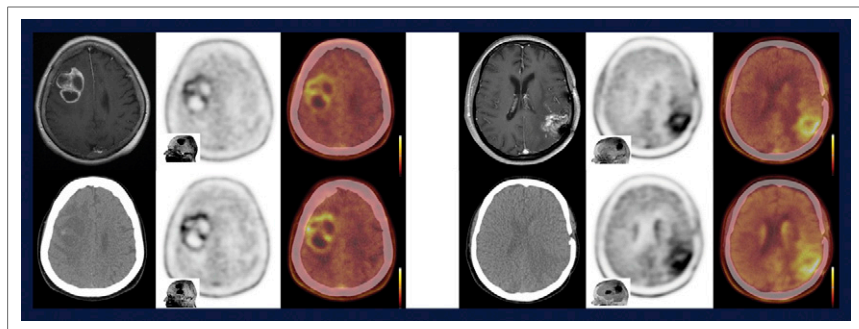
Comparison of ^{18}F -FET and ^{18}F -DOPA in glioblastoma patients. Left block: Primary glioblastoma manifestation. Top, left to right: T1 MR, ^{18}F -FET PET, fusion. Bottom, left to right: CT, ^{18}F -DOPA PET, fusion. Right block: corresponding images in recurrent glioma.
